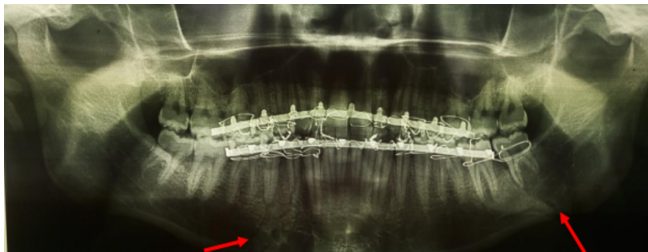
D30 panoramic control radiograph of a 23year old patient
